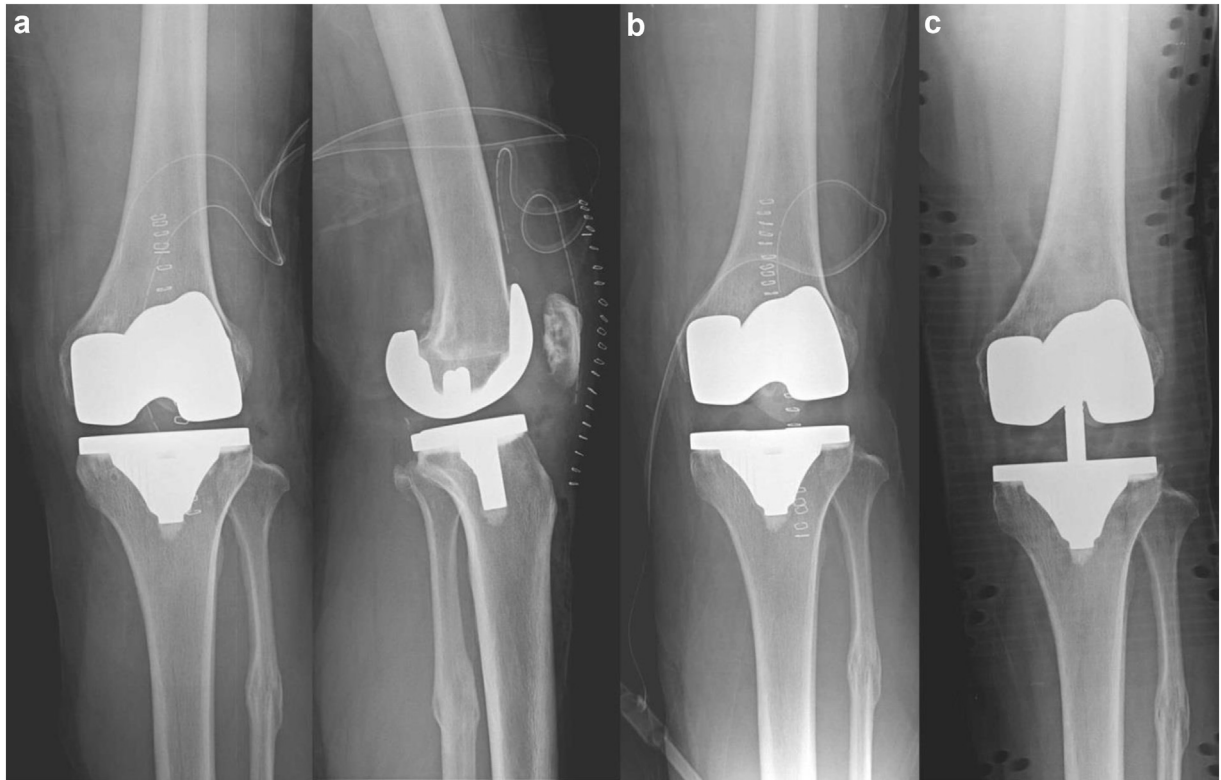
(a) Patient 2. A 59-year-old female underwent left TKA with a 10-mm tibial insert. A lateral radiograph shows a femoral component flexion angle of 5.0° and a posterior tibial slope of 2.4° . (b) She underwent isolated tibial insert exchange with an 18-mm tibial insert following a tibial post fracture. (c) A postoperative radiograph shows exchange for a TS tibial insert with an increased thickness (21 mm) after a tibial post refracture.
